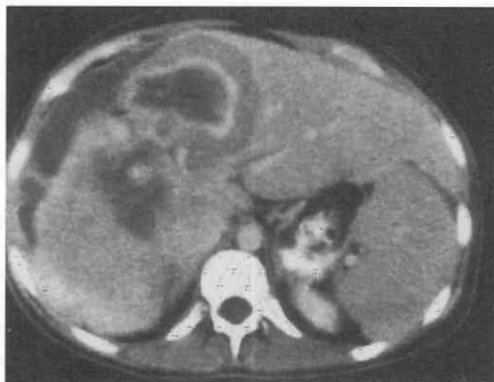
Primary hepatic lymphoma. The contrast-enhanced CT scan shows a large mass of varying attenuation, with contrast enhancement of the tumor lining the necrotic central component. The outer zone of hypovascular tumor remains relatively unenhanced.
